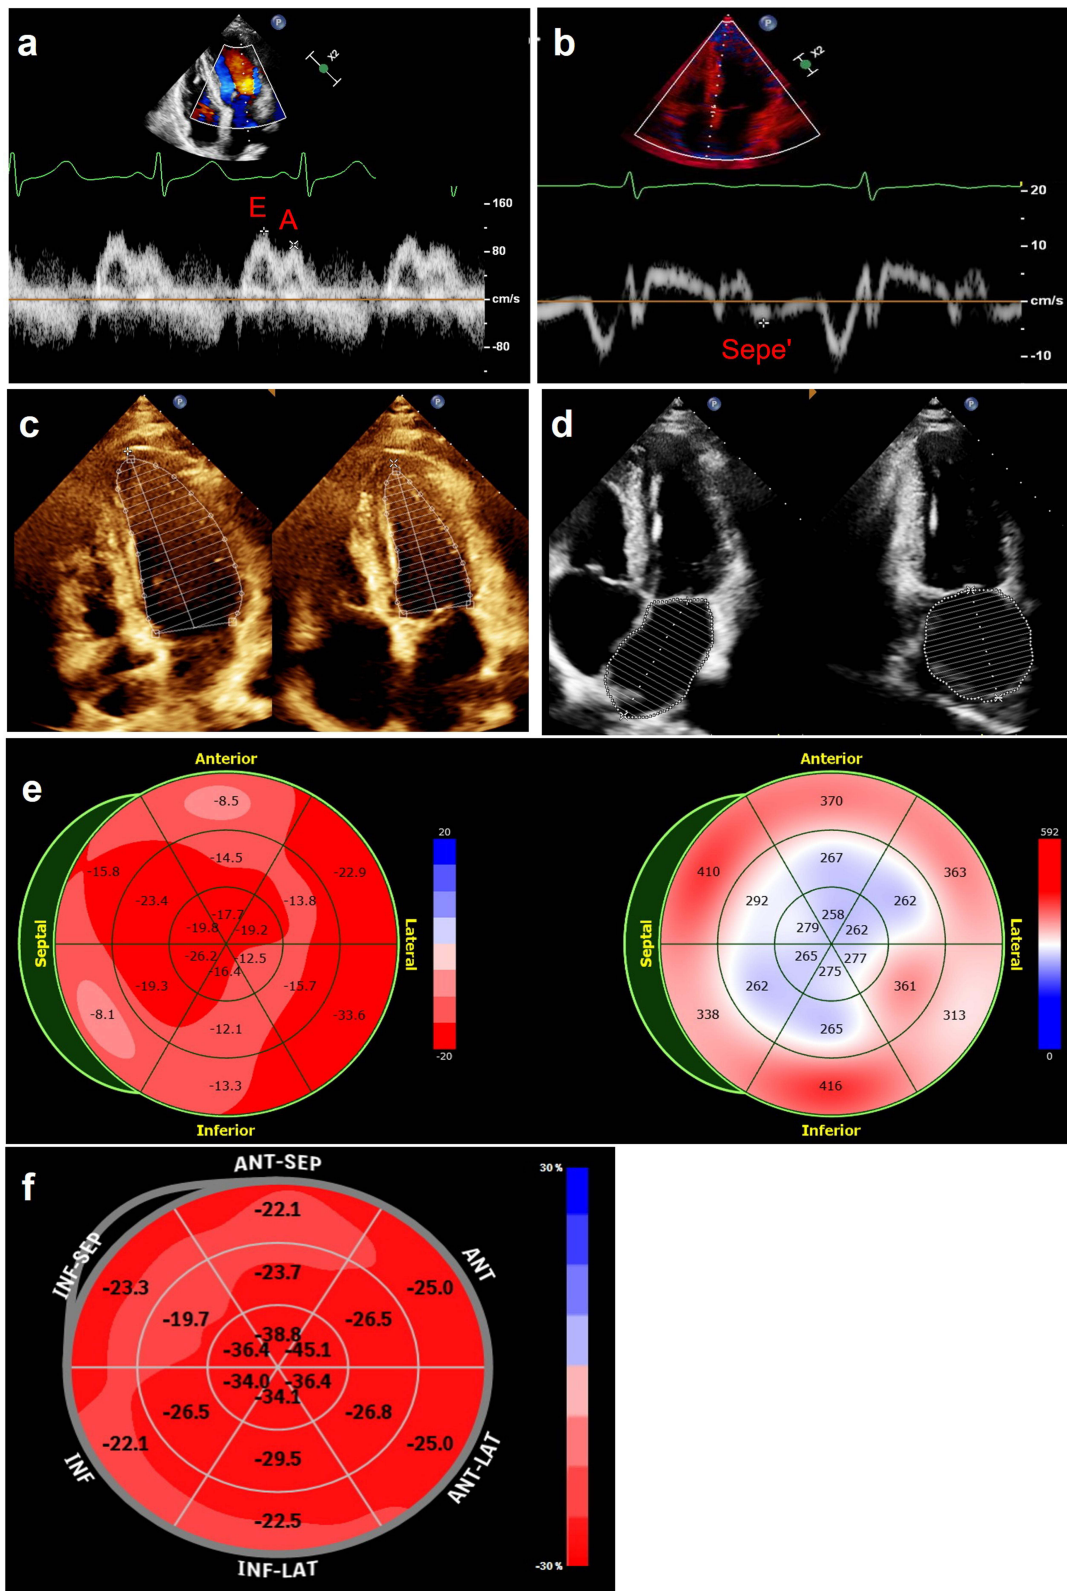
Transthoracic echocardiography in patients with gout. (a) Peak mitral valve velocities in early diastole E and late diastole A were measured using a pulsed Doppler. (b) Doppler measurements of septal mitral annular early diastolic motion velocity (Sepe'). (c) Measurement of left ventricular related parameters by apical biplane Simpson. (d) Left atrial volume and volume index. (e) global longitudinal strain (GLS). (f) Global circumferential strain (GCS). These images were directly exported from the Philips ultrasound system; minor text overlap is inherent to the system-generated output and does not affect measurement accuracy or interpretation.
